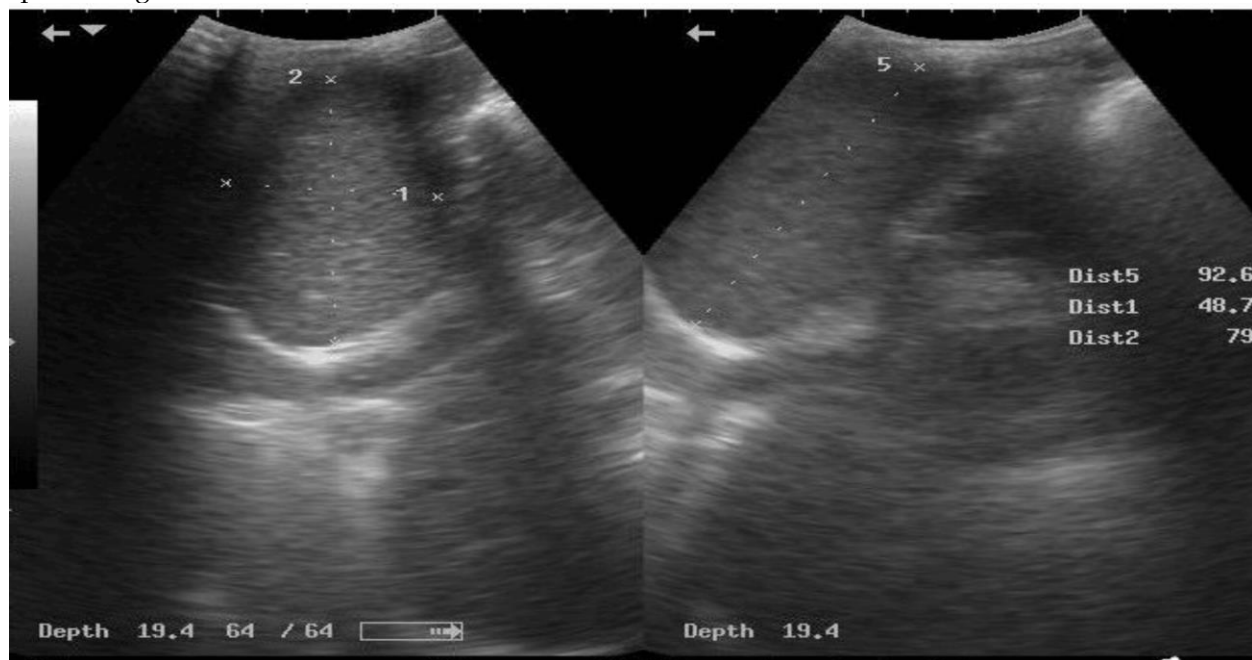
Ultrasound image of the 12-year-old control subject
